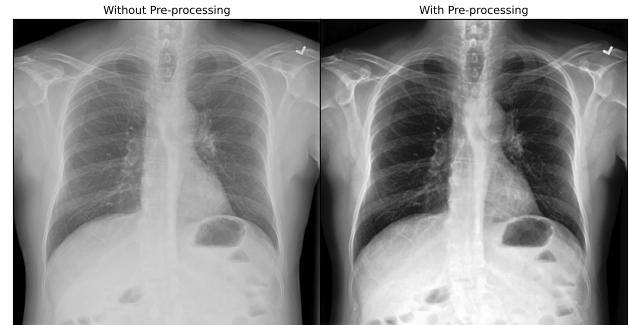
Effect of pre-processing on Chest X-ray images.
